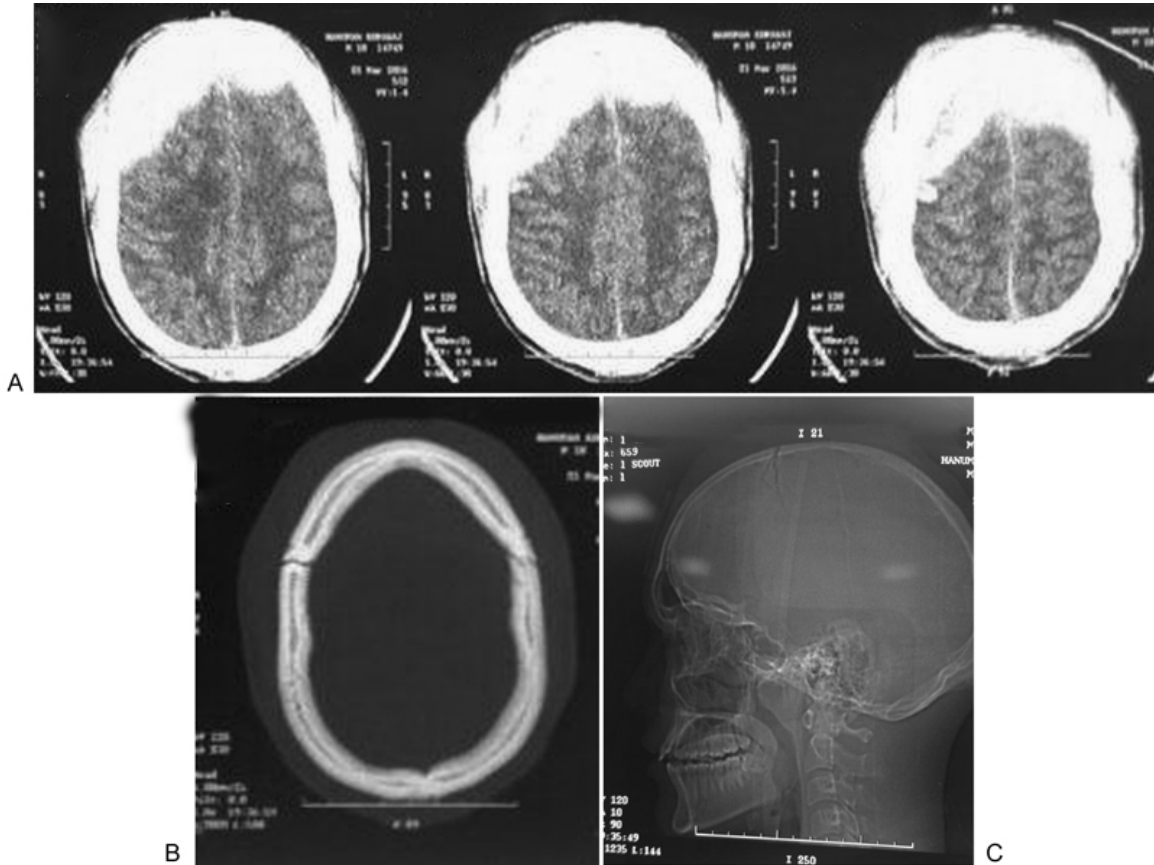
CT brain axial sections (A) showing a large vertex hematoma extending bilaterally. The axial (B) and sagittal (C) bony cuts clearly show coronal suture diastasis (case 3).
